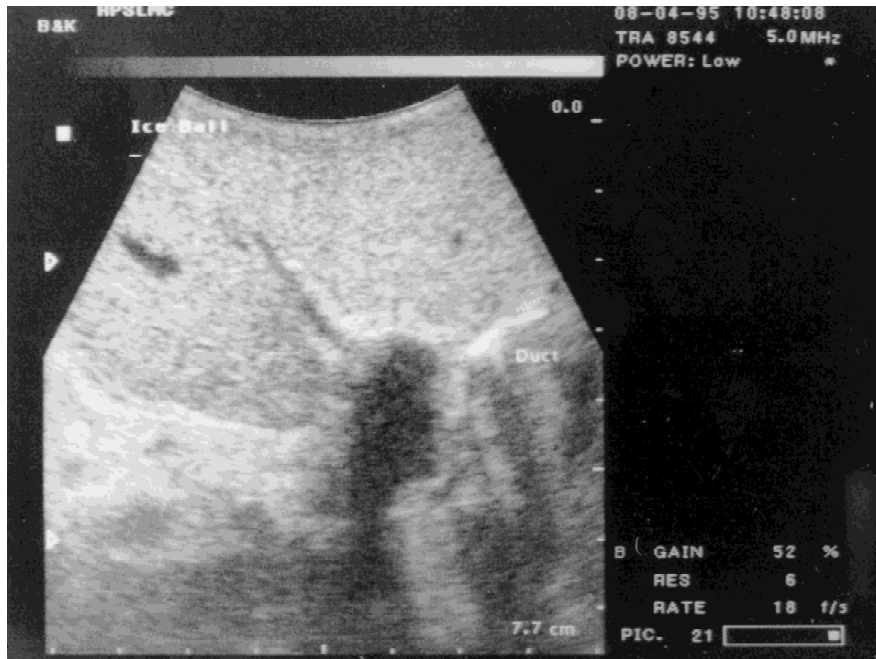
Ultrasound during cryoablation demonstrates the catheter within the left hepatic duct as a bright echo in close proximity to the dark ice ball.
